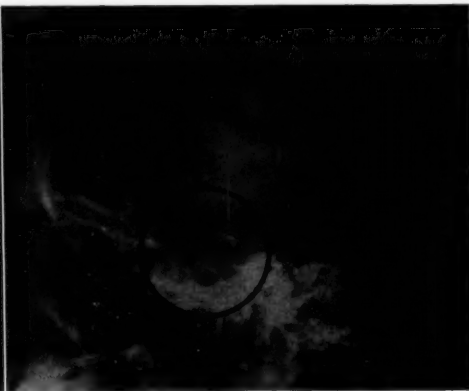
Skull x-ray, October 31, 1936, showing new bone formation in the posterior clinoids and the clivus, and recalcification of the floor of the sella.
